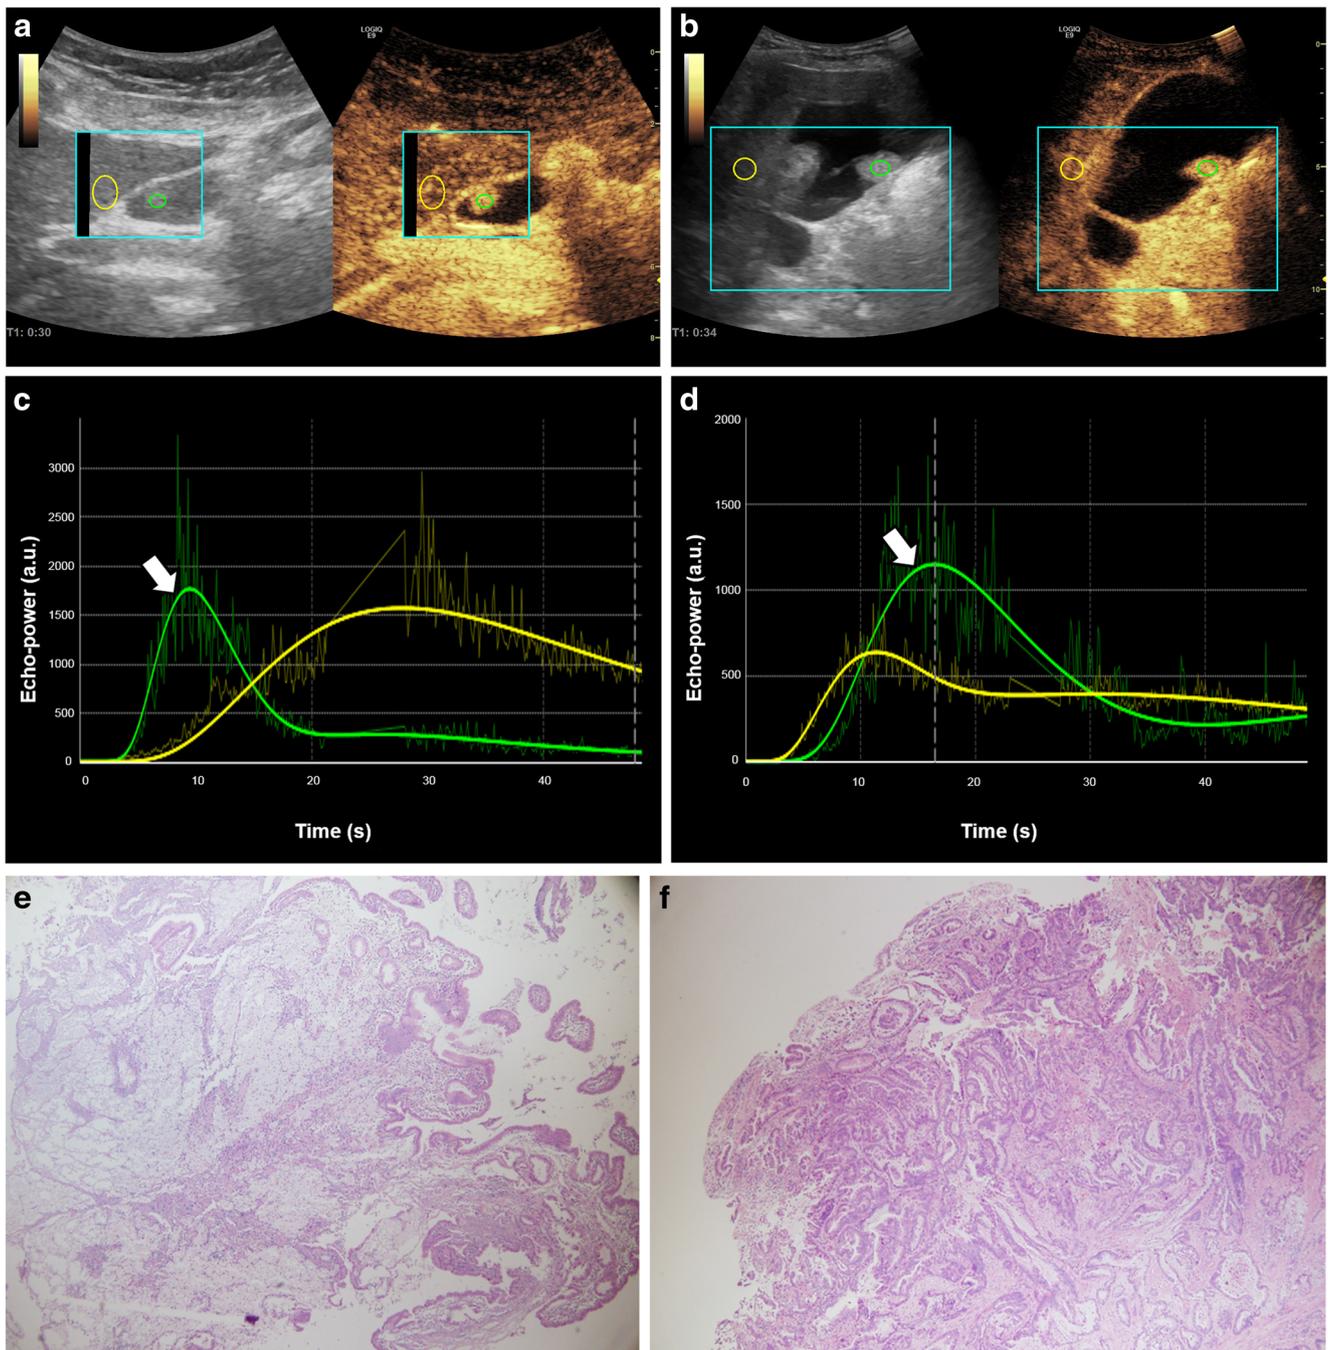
Contrast-enhanced ultrasound (CEUS) examinations in a 28-year-old male patient with a 1.0-cm non-neoplastic gallbladder (GB) polyp (a, c, e) and a 78-year-old male patient with a 1.5-cm neoplastic GB polyp (b, d, f). On CEUS examination, both non-neoplastic polyp (a) and neoplastic polyp (b) showed homogeneous enhancement (arrows) after injection of contrast agent. A green region of interest was placed in the GB polyp and a yellow region of interest was placed in the adjacent hepatic parenchyma at the different level as the GB polyp. On the time-intensity curve acquired through quantitative analysis of the CEUS examination, green
